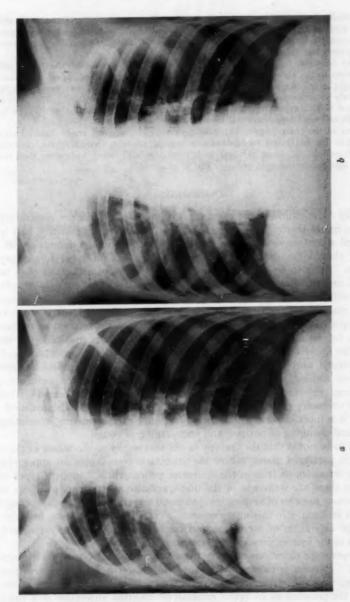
X-ray examination of the chest reveals a right pulmonary atelectasis and infiltration of the right midlung field, probably due to pneumonia. b. Repeat chest x-ray examination three days later demonstrates re-aeration of the right lung atelectasis and resolving right pneumonic process.
